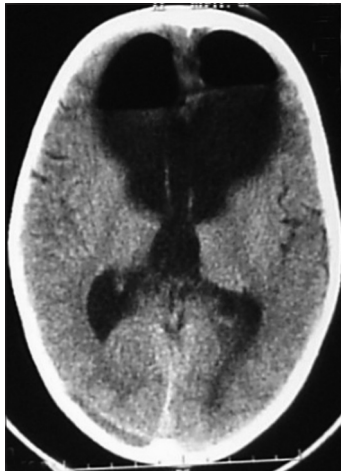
Postoperative contrast CT scan showing no residual tumor in posterior third ventricle with persistent hydrocephalus and pneumocephalus
